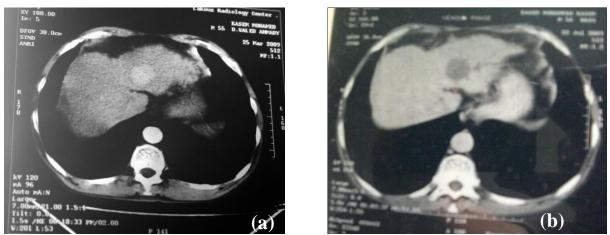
(a) CT study shows HCC with rapid uptake in the arterial phase before treatment. (b) CT study of the same focal lesion shows no uptake (complete ablation) after ethanol injection.
